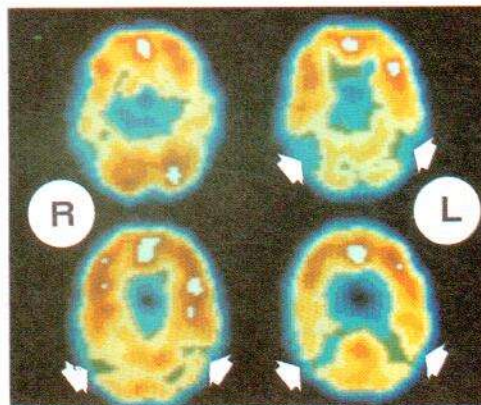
Nine-year-old girl with Lennox-Gastaut syndrome. SPECT showed marked hypoperfusion bilaterally in temporal and parietal lobes.
